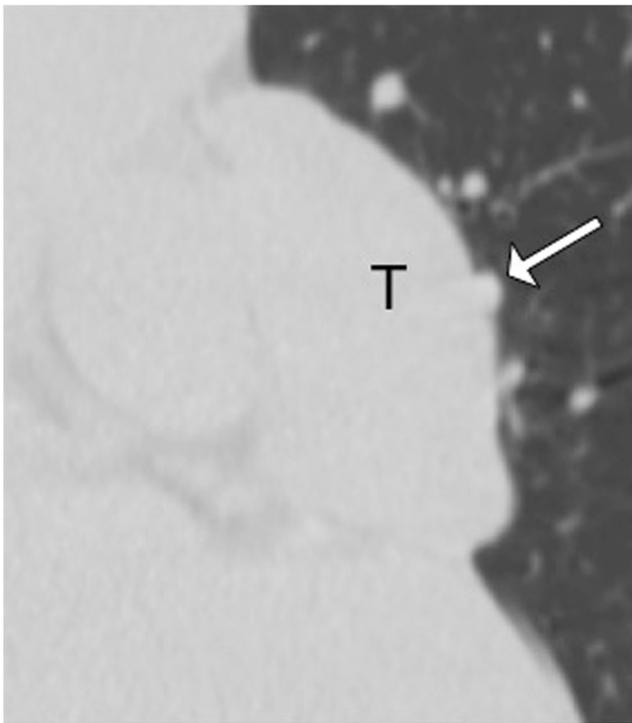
Pulmonary blood vessel mimicking a lobulation. A 49-year-old female with a thymoma that did not invade the lung (T). A pulmonary blood vessel along the left lung interface mimics a focal projection (arrow). A thymoma and blood vessel may have similar attenuation, particularly on a non-contrast CT scan
